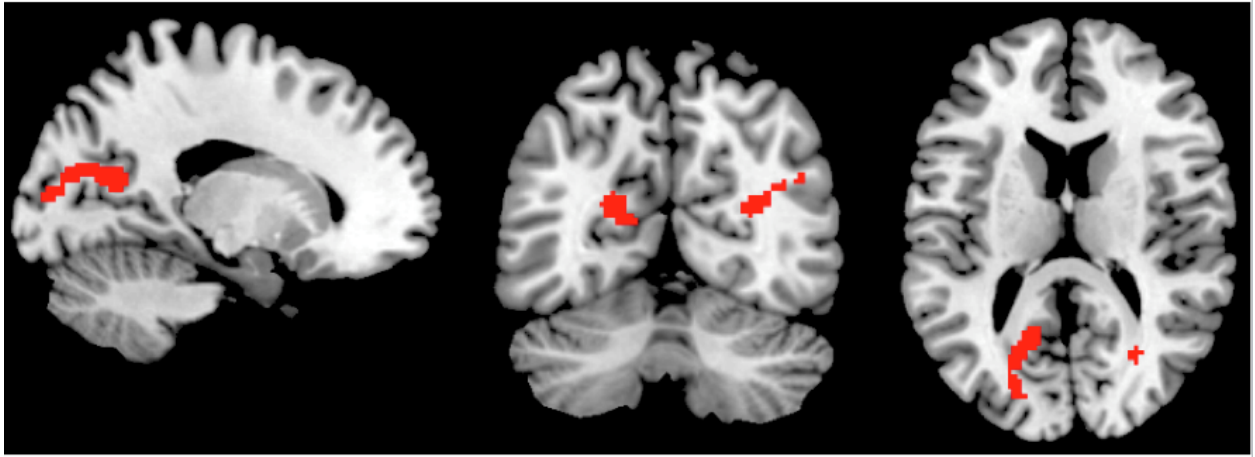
Clusters associated with MRI site and 2-back > 1-back BOLD signal: Cluster threshold $z > 2.3$, $p < .05$.
